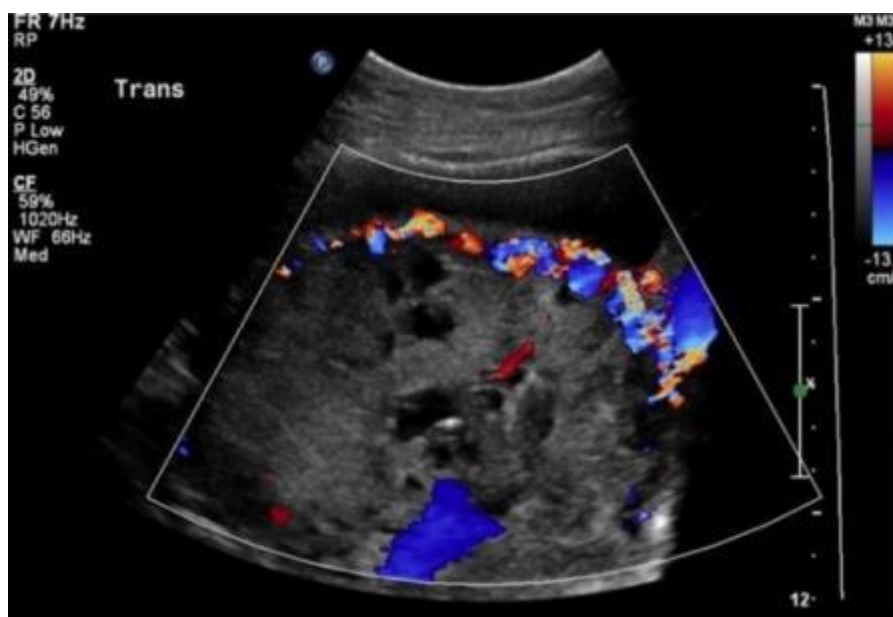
Gray-scale and colour Doppler images showing sonographic diagnostic criteria for morbidly adherent placenta. (a) Clear space: loss/irregularity of echolucent area located between uterus and placenta (arrows). (b) Bladder line: thinning or interruption of hyperechoic interface between uterine serosa and bladder wall (arrows). (C, d) Placental lacunae with turbulent high-velocity flow<sup>(25)</sup>.
